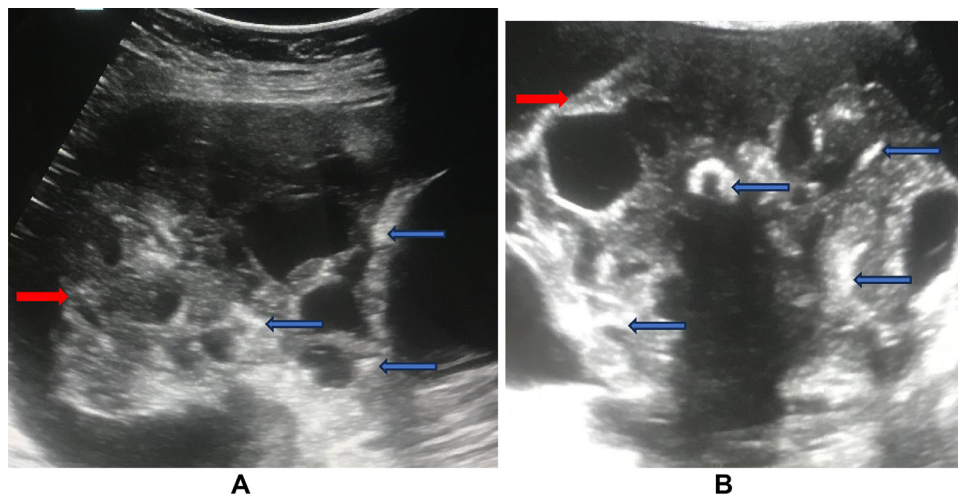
(A and B) Ultrasound of abdomen and pelvis showing ascites and heteroechoic solid-cystic abdominopelvic mass (red arrow) with internal echogenic foci and calcifications (blue arrow).
